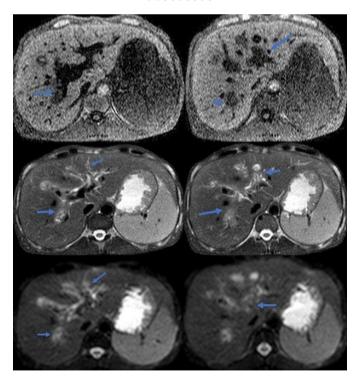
(A-F). MRI axial T1W (A, B), T2W (C, D) & diffusion weighted imaging (E, F) images show thickened walls of intrahepatic bile ducts with pericholangitic oedema suggestive of Cholangio-hepatitis
